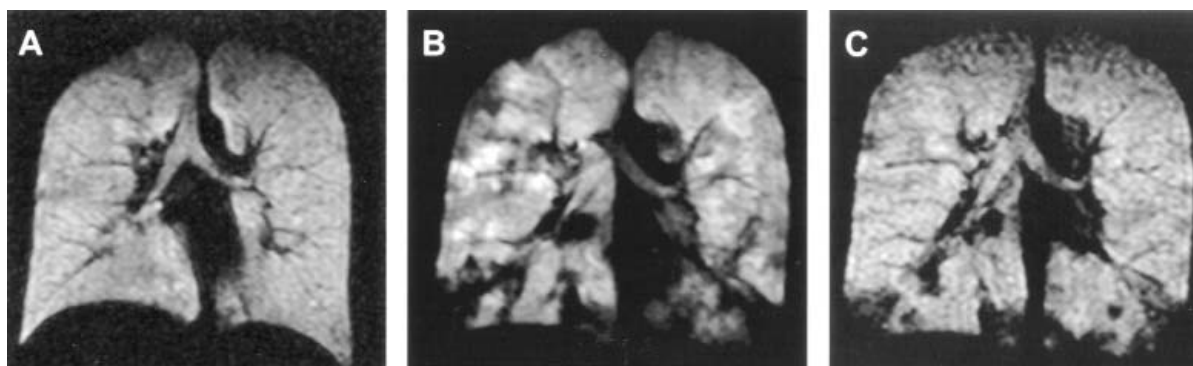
Methacholine challenge. A, Baseline coronal HHe3 MR image of the lungs in a patient with mild asthma (FEV_1 of 118% of predicted value) shows relative homogenous distribution of the gas in the lungs. B, Image obtained after methacholine challenge testing (FEV_1 of 73% of predicted value) demonstrates a large number of ventilation defects. C, Image obtained after inhalation of albuterol shows improvement of the ventilation defects.
